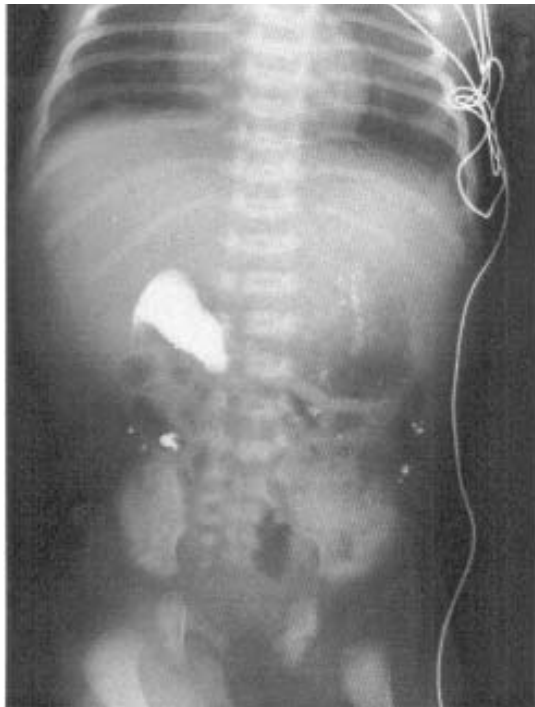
A plain film taken on postoperative day 19 shows a residual concretion in the duodenum, as well as small radio-opaque fragments in the distal bowel.
